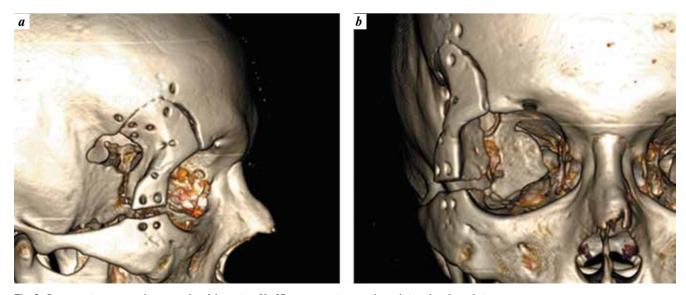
Postoperative computed tomography of the patient \$V\$., \$3D\$ reconstruction: \$a-lateral view; \$b-frontal view\$
